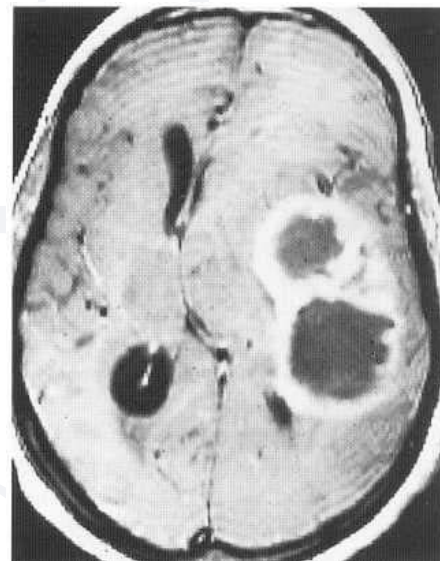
Axial MRI study (T₁-weighted) shows tumour enhancement after IV gadolinium, resembling enhanced CT study. Mass effect and herniation under the falx are well shown. Glioblastoma multiforme.
